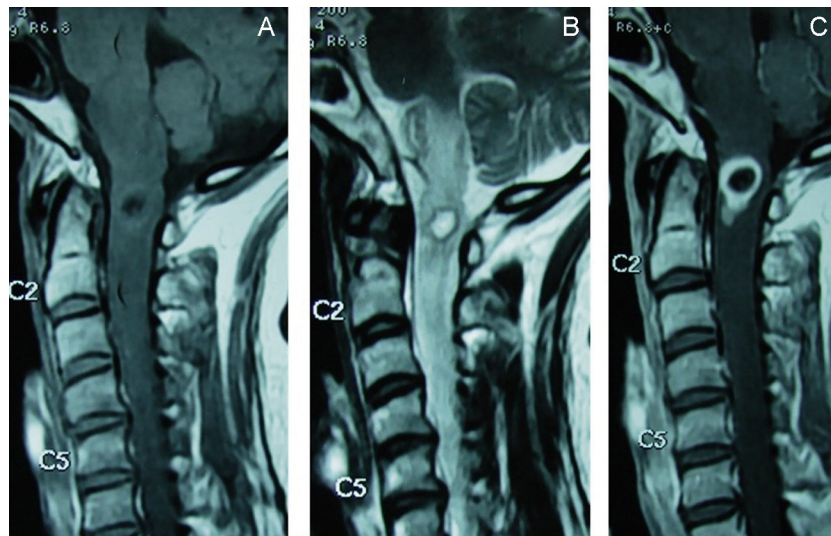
(A) MRI of cervical spine T1W sagittal image showing hypointense lesion with hyperintense rim at craniovertebral junction. (B) MRI of cervical spine T2W sagittal image showing hyperintense lesion with hypointense rim at craniovertebral junction. (C) MRI of cervical spine T1W+ contrast sagittal image showing thick ring enhancing lesion at craniovertebral junction.
